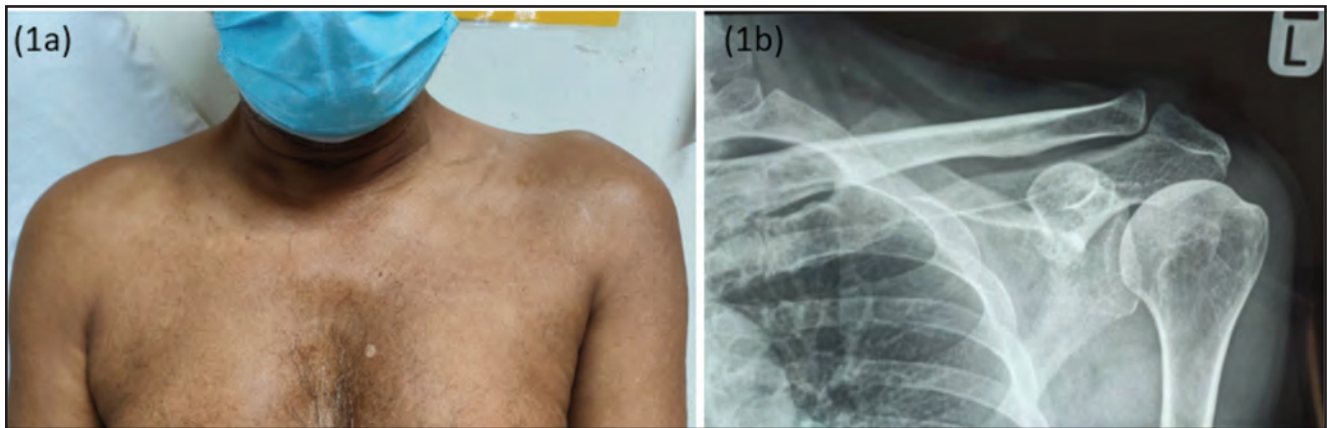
(A) A localised swelling over the left ACJ with no overlying erythema.* (B) Plain radiograph of the left shoulder with no discernible intra- or peri-articular abnormality. There was a mild increase in soft tissue shadow over the ACJ.
